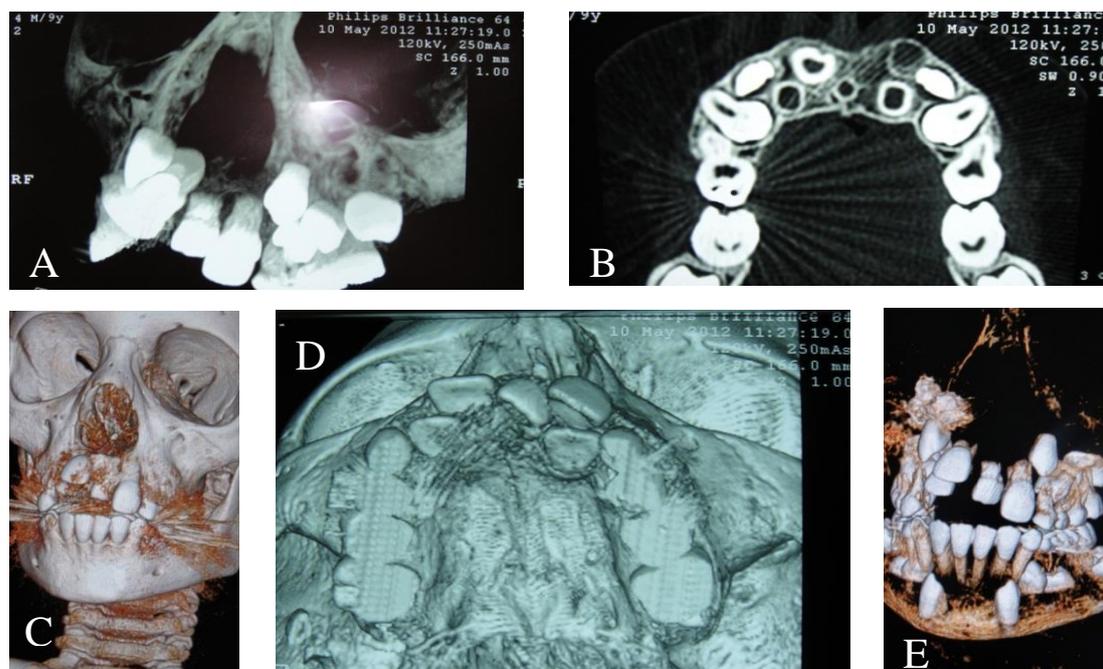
Dental 3D Software CT with multiplaner reconstruction of premaxilla demonstrating a multiple anterior impacted teeth for the patient aged 12 year A. frontal view B. axial slice C. and D. 3D CT frontal images and E. 3D CT axial view of maxilla.
